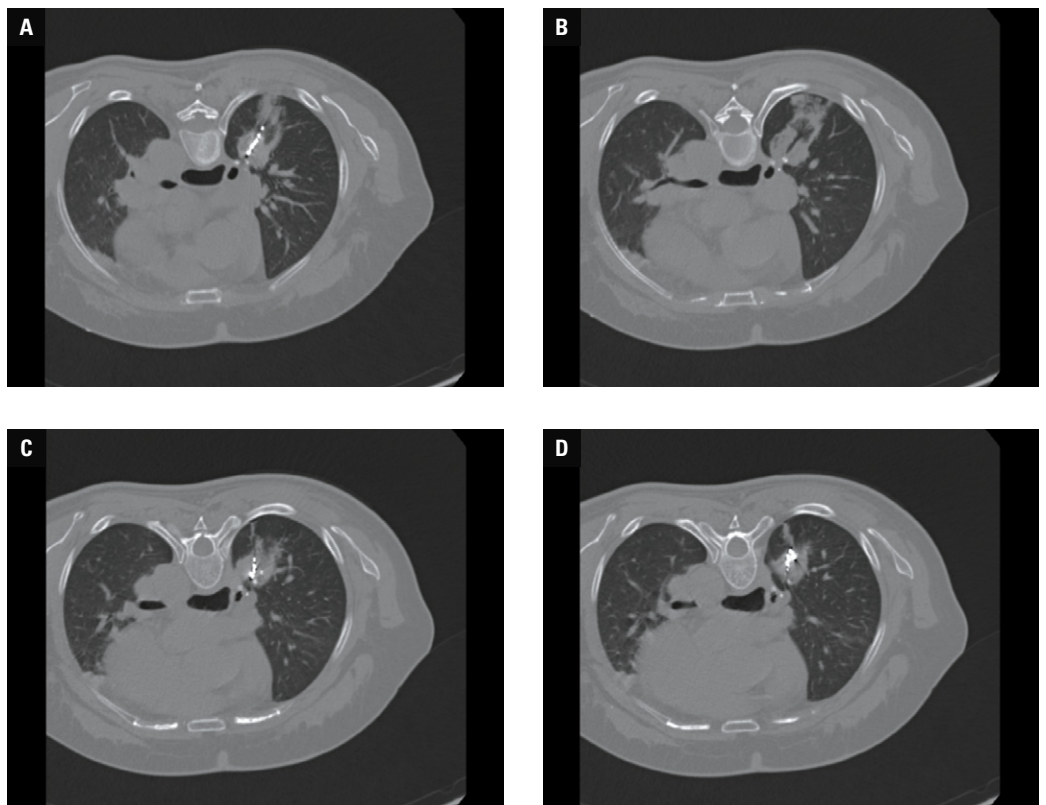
A–D – chest computed tomography performed 10 minutes after microwave ablation combined with particle implantation, showing a satisfactory ablation area, uniform particle implantation distribution, and minimal bleeding from the needle tract
